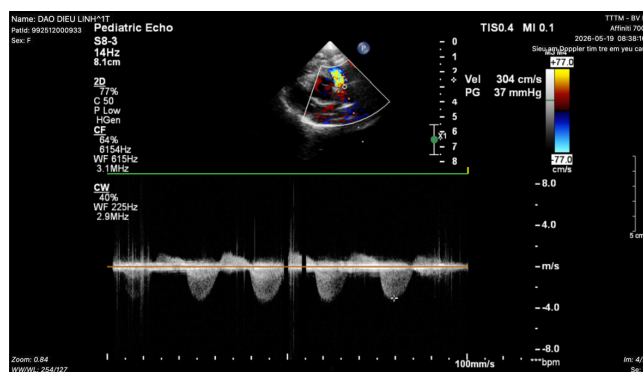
Doppler echocardiography at 3-month follow-up demonstrating satisfactory right ventricular outflow tract flow with only mild residual obstruction (peak gradient 37 mmHg)
